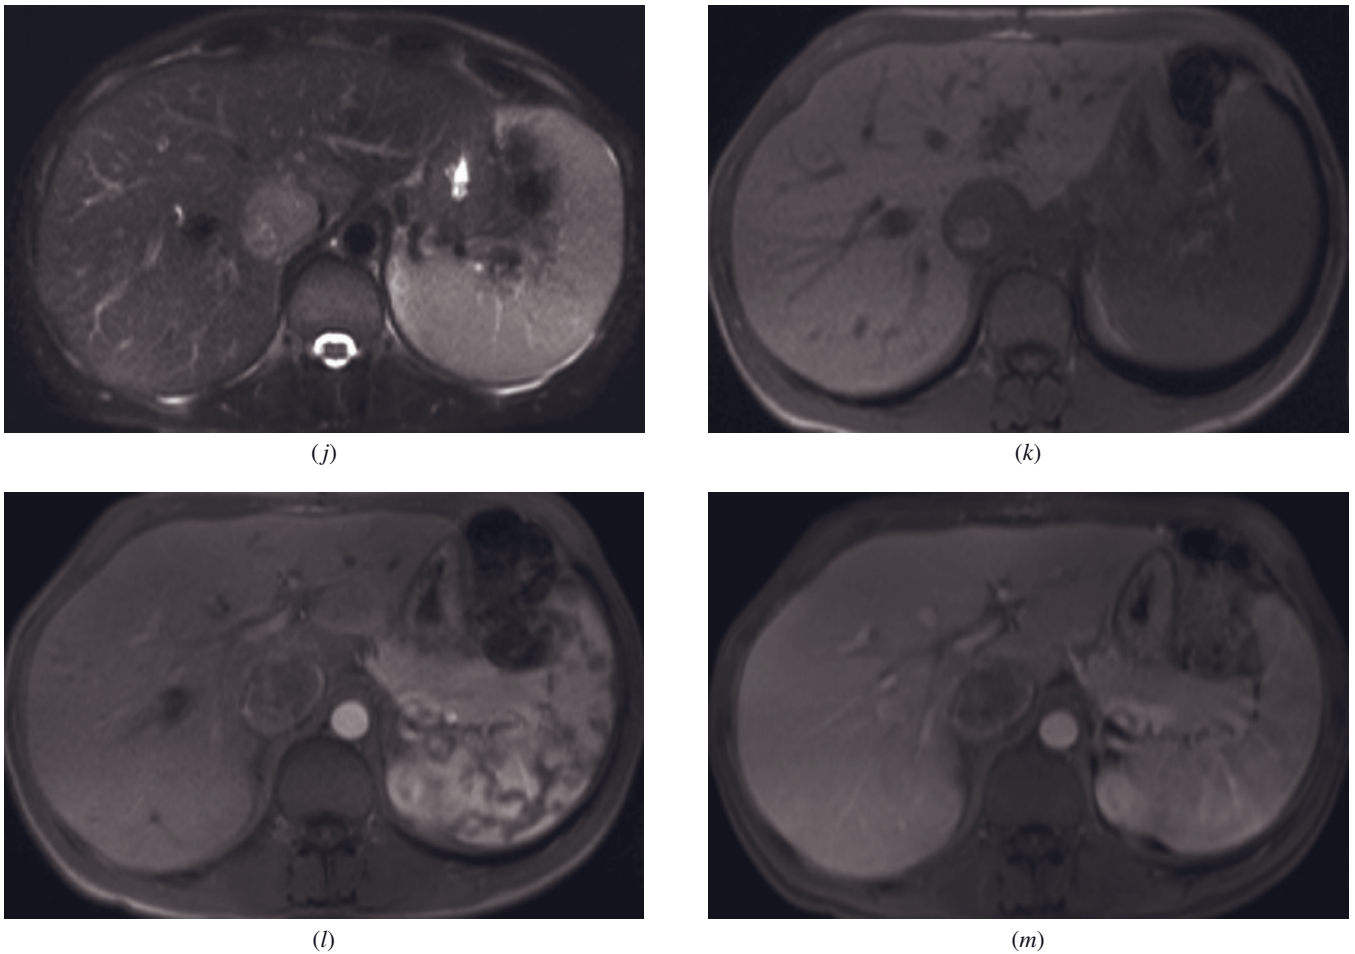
(Continued) spin-echo (*j*), T1-weighted in-phase SGE (*k*), T1-weighted postgadolinium hepatic arterial dominant-phase SGE (*l*), and T1-weighted postgadolinium hepatic venous-phase fat-suppressed 3D-GE (*m*) images demonstrate the tumor thrombus in the IVC developing secondary to adrenocortical carcinoma in another patient. The thrombus is heterogeneous on precontrast images (*j*, *k*) and shows heterogeneous enhancement on postgadolinium images (*l*, *m*).
